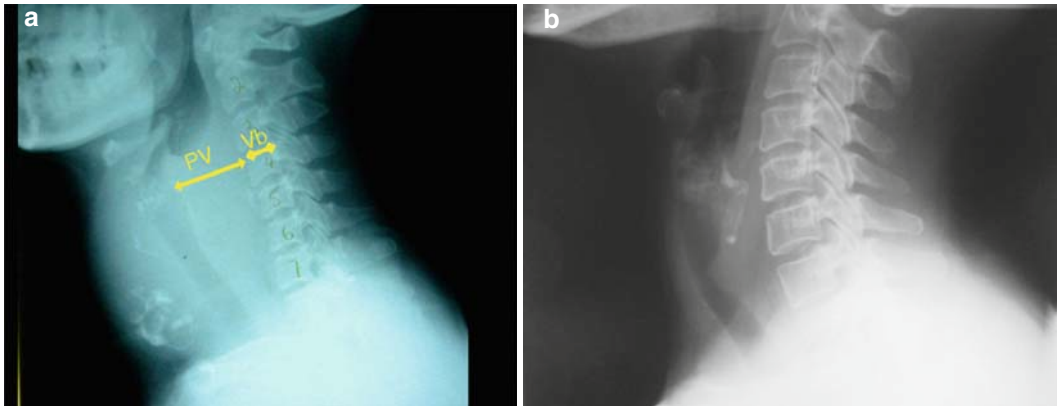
(A) The widening of retro-visceral or prevertebral soft tissue measurement at C4 level is the most promising predictor of enlarged Zuckerkindl's tubercle. (B) Lateral radiograph showing direct posterior compression narrowing the airway with severe symptoms of dyspnea, stridor, and dysphagia.
